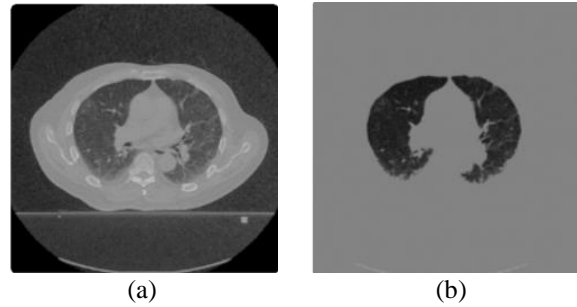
CT images (a) original and (b) after lung segmentation
